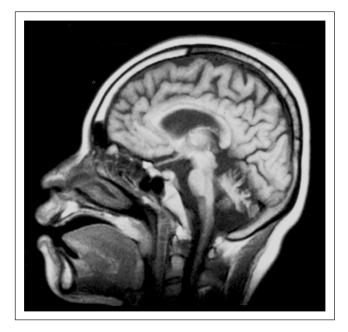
Brain MRI (sagittal TI-weighted) at age 27 years. MRI shows the atrophy of the cerebellum and cerebrum.
